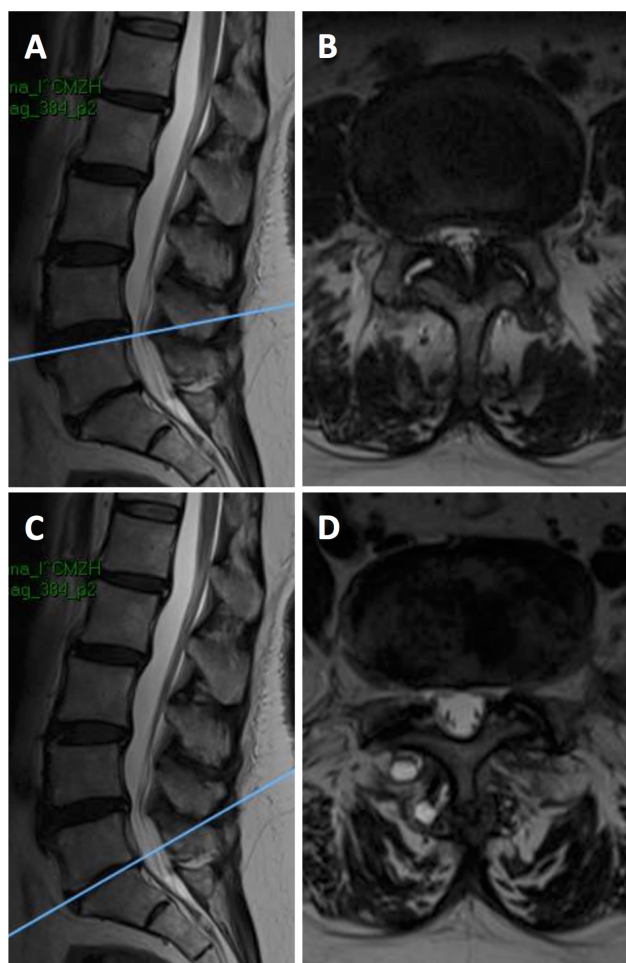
Magnetic resonance image showing lumbar spinal stenosis. Sagittal (A) and axial (B) T2-weighted images showing lumbar spinal stenosis at L4/L5 secondary to ligamentum flavum hypertrophy and bilateral facet arthropathy. Sagittal (C) and axial (D) T2-weighted images showing foraminal stenosis on the left secondary to facet arthropathy at L5/S1.
